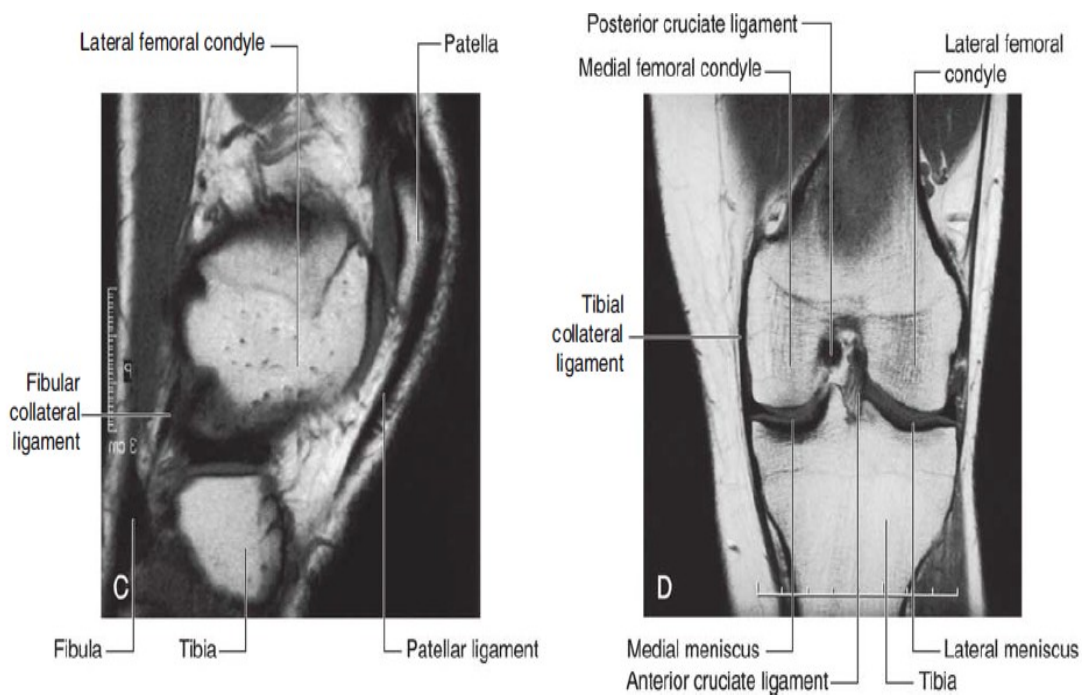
C : Sagittal T1 weighted MR image showing normal fibular collateral ligament & patellar ligament
